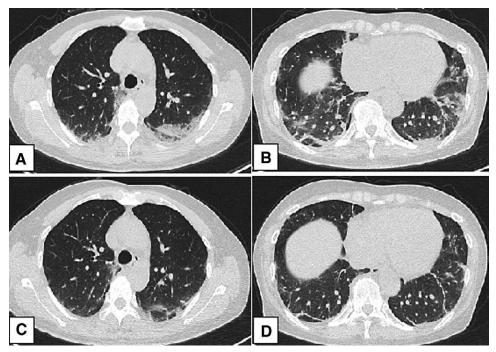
Case 3. On the seventh day of admission (9 days after onset), chest computed tomography demonstrated multiple patchy and nodular ground-glass opacities and consolidation and linear opacities in the bilateral lungs, mainly in the subpleural area (A, B). The lung lesions were greatly absorbed at 40 h after the plasma treatment (C, D).
